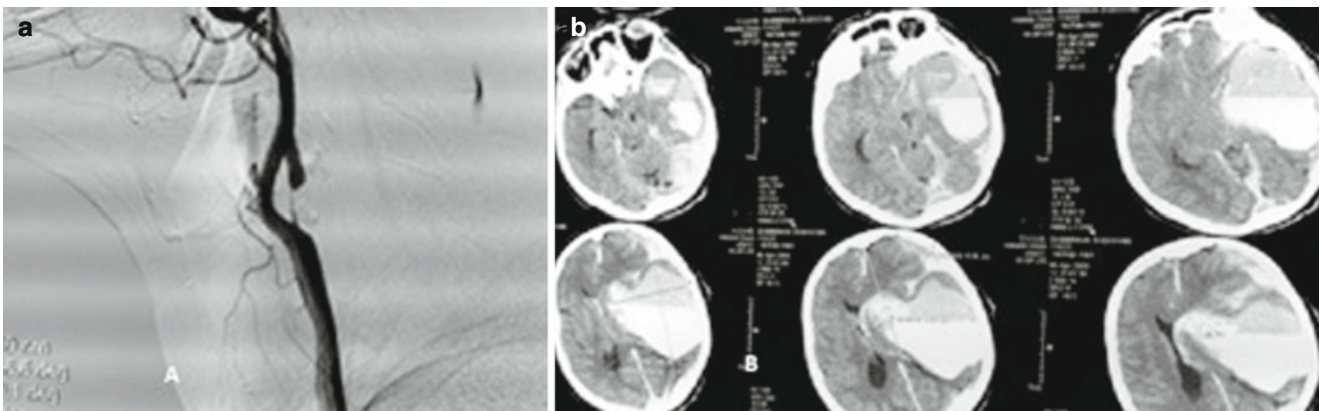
Severe reperfusion syndrome: panel (a) initial carotidogram showing severe left ICA stenosis; panel (b) CT scan obtained 30 min after successful CAS
